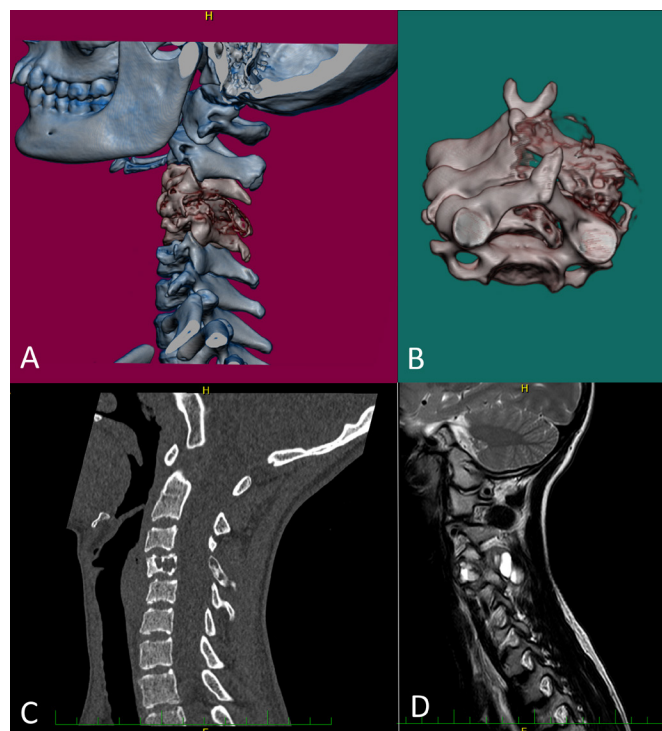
Imaging methods showing aneurysmal bone cyst (ABC) case with *IP6K2::USP6* gene fusion. (A) Three-dimensional (3D) reconstruction of CT scan showing the vertebra C4 involvement, side view. (B) 3D reconstruction of CT scan showing the C4 vertebra involvement, top view. (C) CT showing osteolytic lesion of the vertebra C4. (D) MRI showing a heterogenic mass in the vertebra C4.
